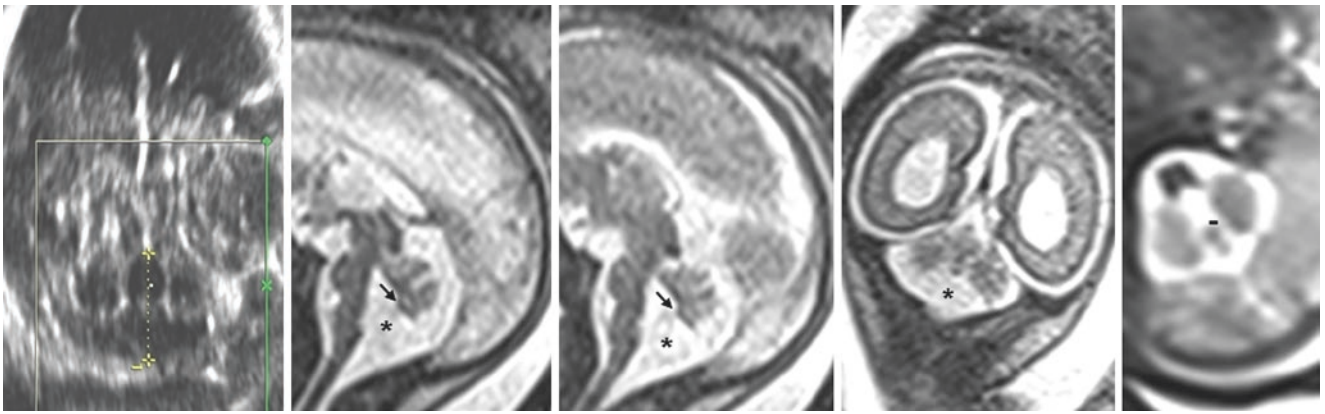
Comparison case of inferior cerebellar vermian hypoplasia (ICVH). A 19-week-old fetus underwent an MRI for an abnormal posterior fossa on US (*left*). A retrocerebellar and infracerebellar cystic dilatation (*) was noted on T2WIs in the sagittal (*left middle and mid-*
